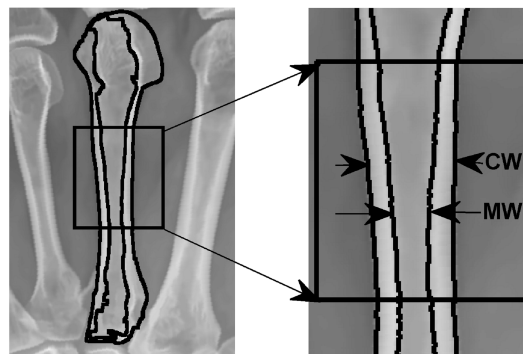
Radiogrammetric measurement of third metacarpal bone using hand radiograph
